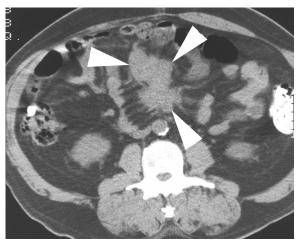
Sclerosing mesenteritis. Axial CT scan shows an irregular soft-tissue mass in the root of the mesentery (arrowheads).
